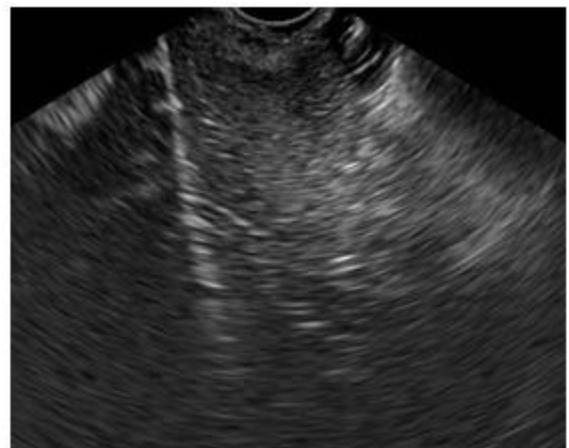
Intraoperative ultrasonography (gross total excision)
